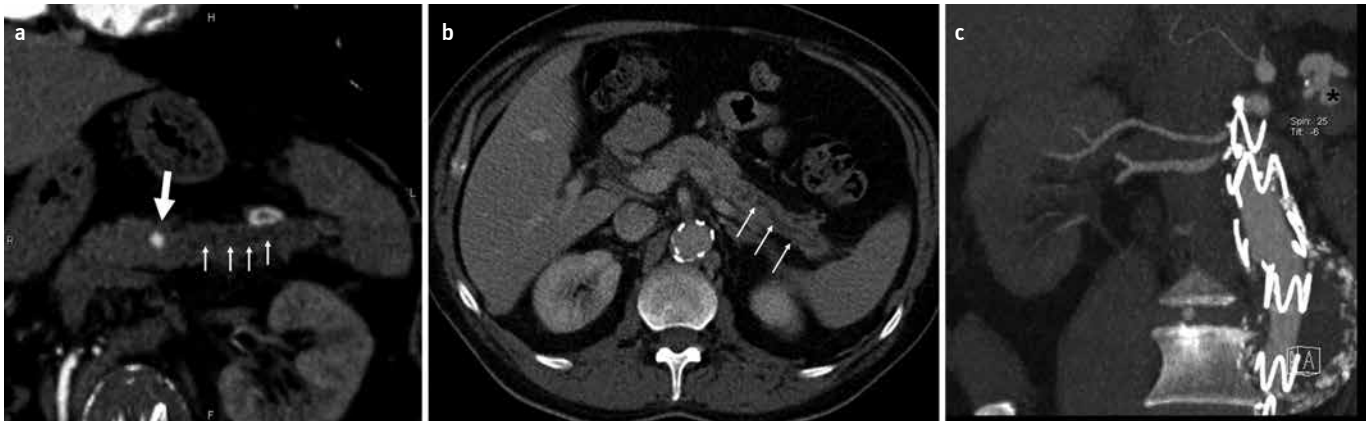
a-c. Arterial (a) and venous (b) phase images from an abdominal CT. An intrapancreatic splenic artery aneurysm (big arrow) is seen in a close association with the main pancreatic duct. Also note the dilation of the main pancreatic duct and changes suggesting chronic pancreatitis along the tail of the pancreas (small arrows) distal to the pseudoaneurysm. (c). MPR image for documenting the patency of the right renal arteries showing the splenic artery aneurysm (*) in this patient who previously underwent EVAR.
